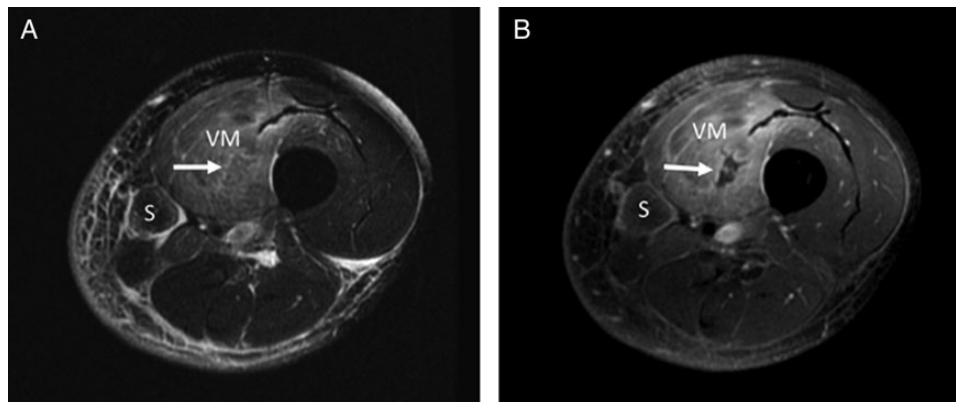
Follow-up magnetic resonance imaging (MRI) 4 days later. Axial T2 (A) and T1-weighted (B) images with fat saturation through the left mid-thigh after intravenous gadolinium administration demonstrate persistent edema and enhancement in the anteromedial thigh musculature, with a swollen and edematous vastus medialis (VM). However, there is now a small focus of nonenhancing muscle in the vastus medialis muscle (arrow) but no corresponding high signal intensity fluid collection on the T2-weighted image (arrow). Decreased edema and enhancement is seen in the subcutaneous tissues compared with the MRI scan 4 days earlier.
